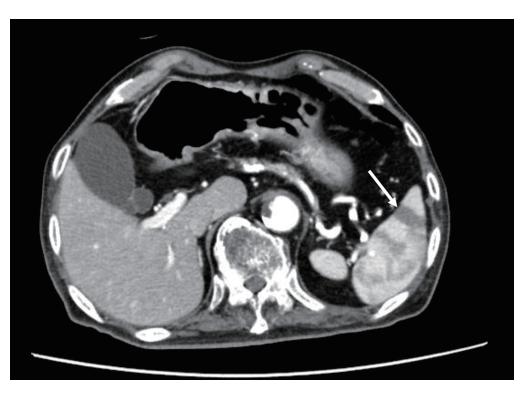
The contrast-enhanced CT scan finding of patients with splenic infarction. The arrow indicates splenic infarction. CT: computed tomography.
